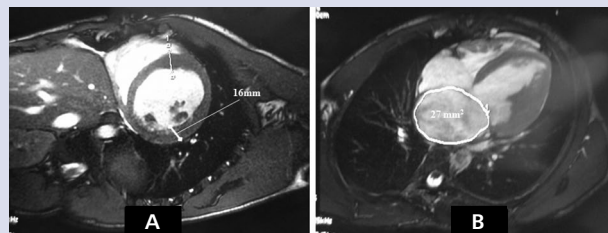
Cardiac magnetic resonance imaging showing a hypertrophic basal inferior segment (A) and a dilated left atrium (B)
